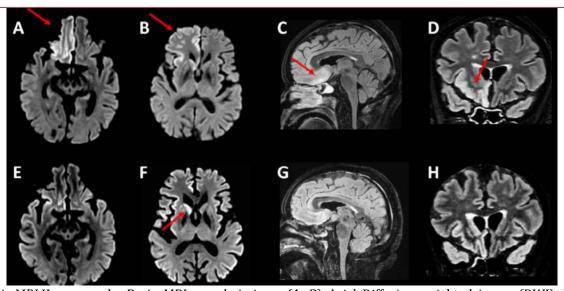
Brain MRI Upper panel: Brain MRI on admission: (A, B) Axial Diffusion-weighted image (DWI) showing right orbitofrontal cortex and caudate nucleus hyperintensity (tip of the red arrow). (C) Sagital fluid-attenuated inversion recovery (T2/FLAIR) showing right orbitofrontal cortico subcortical hyperintensity toward caudate nucleus (tip of the red arrow). (D) Coronal T2/FLAIR showing an orbitofrontal hyperintensity (tip of the red arrow). Lower panel: Brain MRI on day 15: (E, F) Axial DWI showing decrease of the hyperintensity within the right orbitofrontal cortex but persistance on the right caudate nucleus (tip of the red arrow). (G) Sagital and (H) coronal T2/FLAIR showing decrease of the hyperintensity within the right orbitofrontal cortex.
